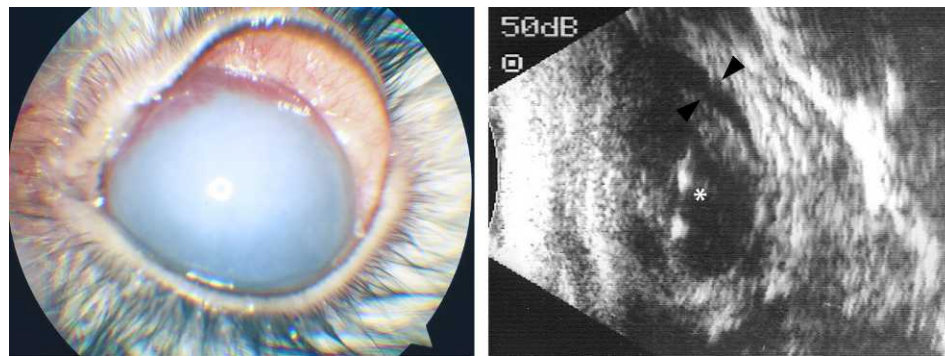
Rabbit's left-eye anterior segment (*left*) shows conjunctivitis, inflammatory exudate into the anterior chamber aqueous humor and corneal opacities, ultrasonography (*right*) shows exudative retinal detachment (*arrowheads*) and vitreous opacities (*asterisk*) at day 45 after SC-only inoculation of the eye with CT (SC+IV group).
